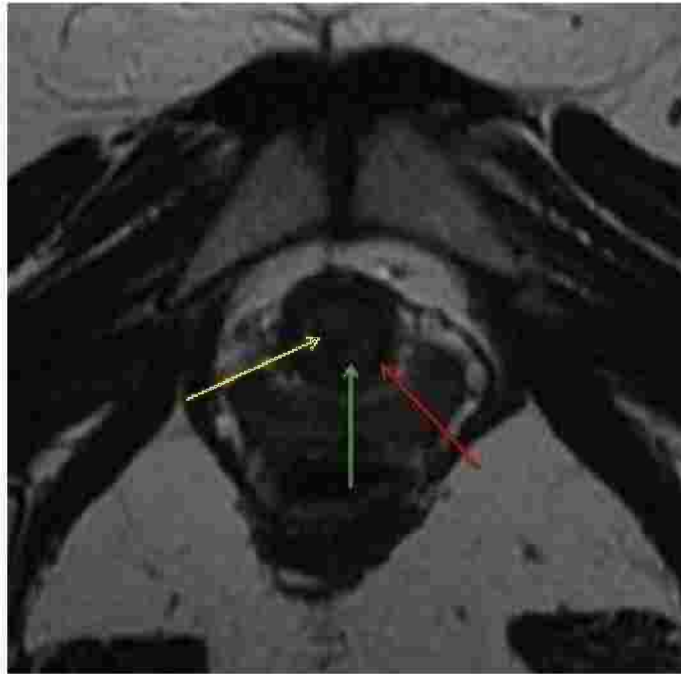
Normal urethral zonal anatomy. Axial T2-weighted MR image shows a target-like appearance secondary to inner hypointense mucosal layer (yellow arrow), middle hyperintense submucosal layer (green arrow), and outer hypointense muscular layer (red arrow).
